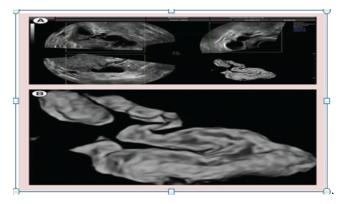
Inversion mode from a hydrosalpinx. The sausagelikeform is clearly depicted using this display mode. (A) 3D ultrasonography and (B) inverse mode of a hydrosalpinx.
